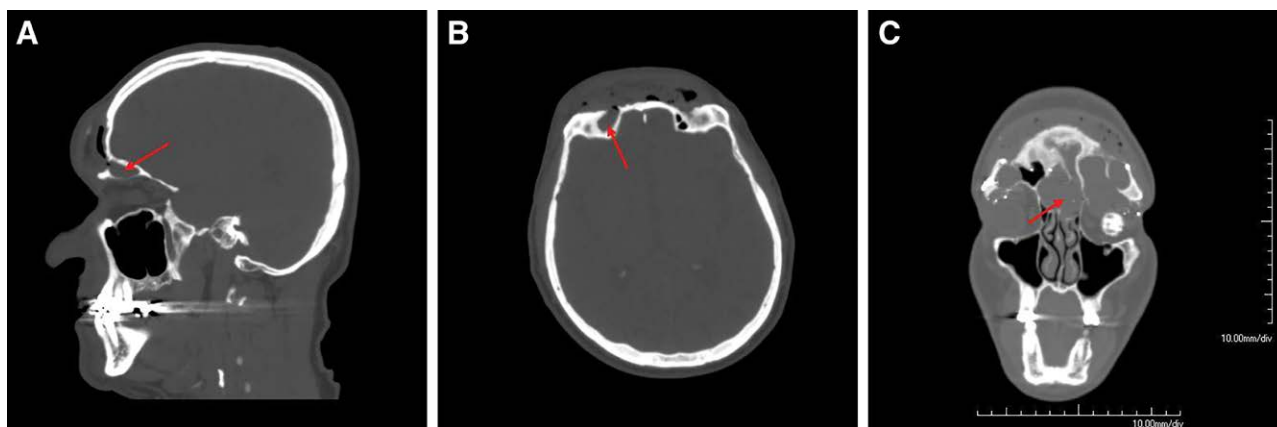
CT scan showing mucocoele. A (sagittal view) and B (axial view) demonstrate mucocoele communication with the remnant frontal sinus (red arrow). C (coronal view) demonstrates mucocoele (red arrow) causing displacement of left eye prosthesis. Published with permission from and copyrights retained by Eduardo D. Rodriguez, MD, DDS.
